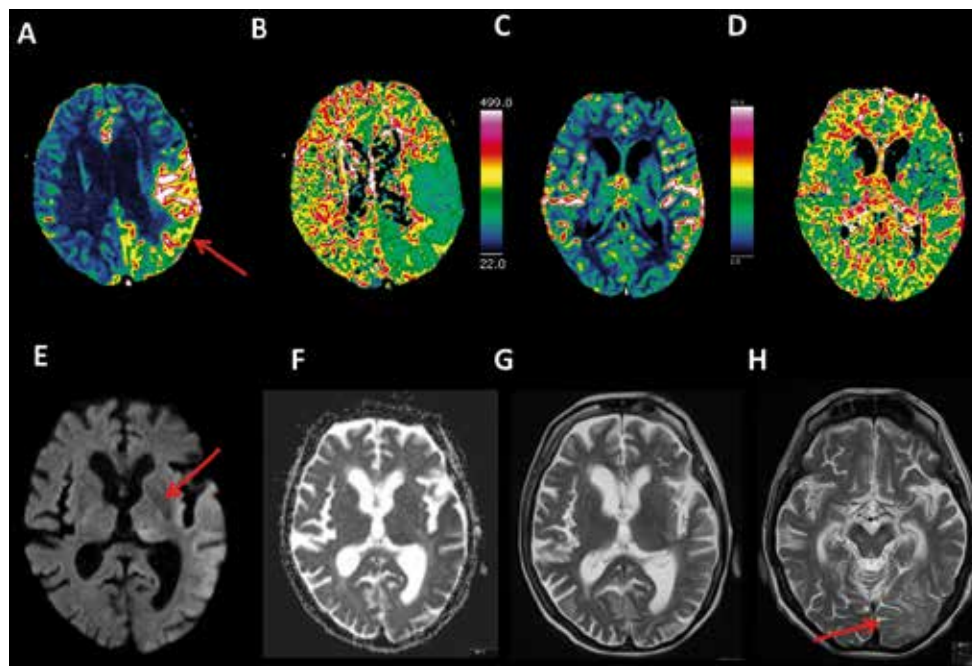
67 year old male with acute sensomotoric aphasia and hemiparesis on the right since 2 hours, EEG documents left seizure activity with temporal dominance leading to an electroclinical diagnosis of NCSE. A-D increased CBF of the left hemisphere temporo-parieto-occipital (A,C) and MTT shortening (B,D), E-G cytotoxic edema temporo-parieto-occipital and pulvinar thalami, H- follow-up MRI: vasogenic edema left occipital. Patient with inaugural NCSE without documented preceding generalized tonic-clonic seizure. Here, hyperperfusion without territorial distribution initiated the EEG-based diagnosis of NCSE.
